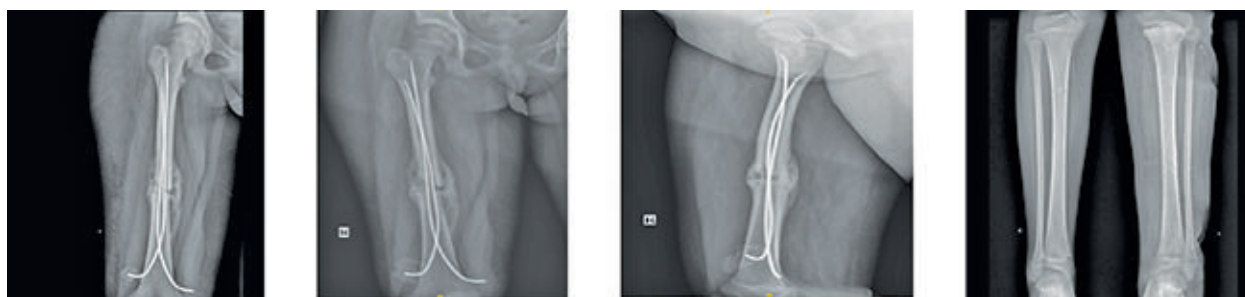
X-rays show good uniting state
